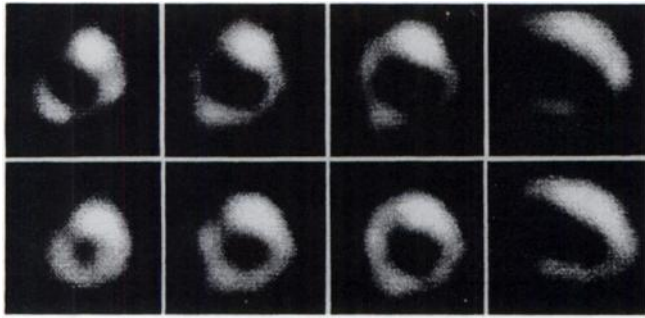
Rest redistribution SPECT thallium images in a patient with severe left ventricular dysfunction and three-vessel coronary artery disease proven by angiography. (Upper Panel) Initial rest images. (Lower Panel) Four-hour redistribution images. Three short-axis slices at the apical, mid and basal level of the left ventricle and the vertical long-axis slice at the mid-left ventricular level are shown. There are extensive perfusion abnormalities in the initial images which show partial to complete redistribution. Left ventricular ejection fraction in this patient was 23% before and 53% 7 days after coronary artery bypass grafting.
